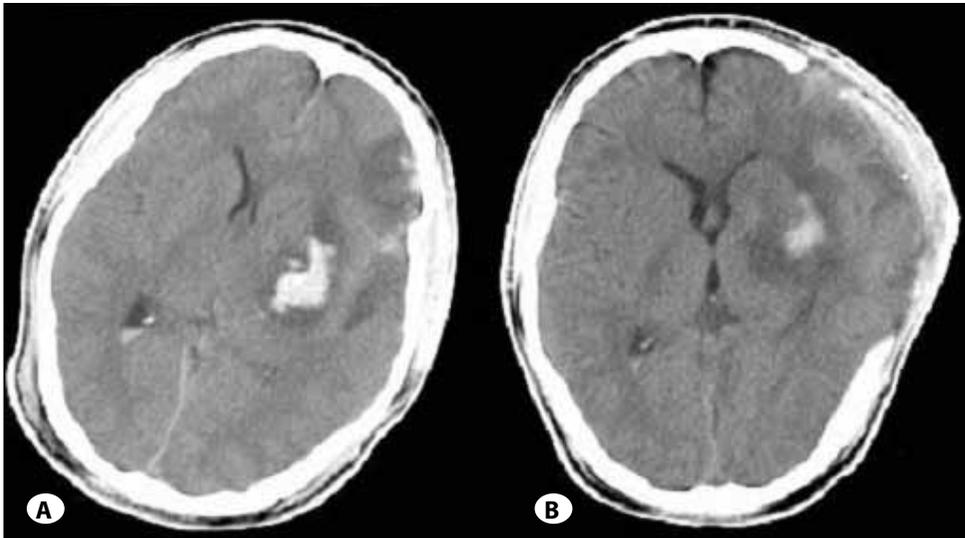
Pre- and postoperative computed tomography(CT) scan of type III (A) Preoperative CT scan demonstrating contusion, small hematoma and brain edema in left eloquent regions with compressed ventricles. (B) Postoperative CT scan showing outward shift of the hematoma and decreased compression of ventricles after DC combined with anterior temporal lobe resection.
